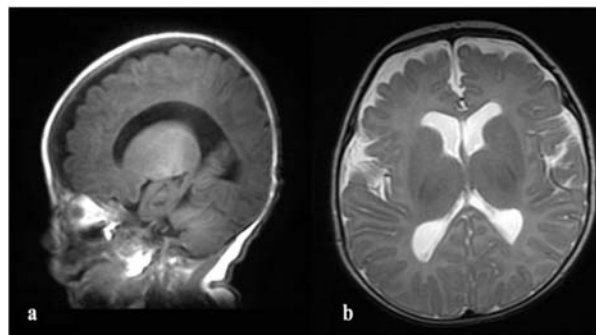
Magnetic resonance image (MRI) sagittal plane (a) showing absence of corpus callosum, and axial plane (b) showing mild ventriculomegaly.
